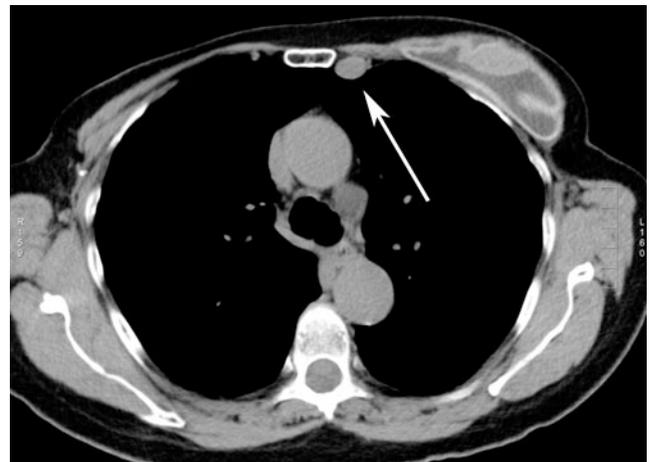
Axial noncontrast CT image showing an enlarged left internal mammary lymph node (arrow) measuring 1.6 x 2.1 cm.
